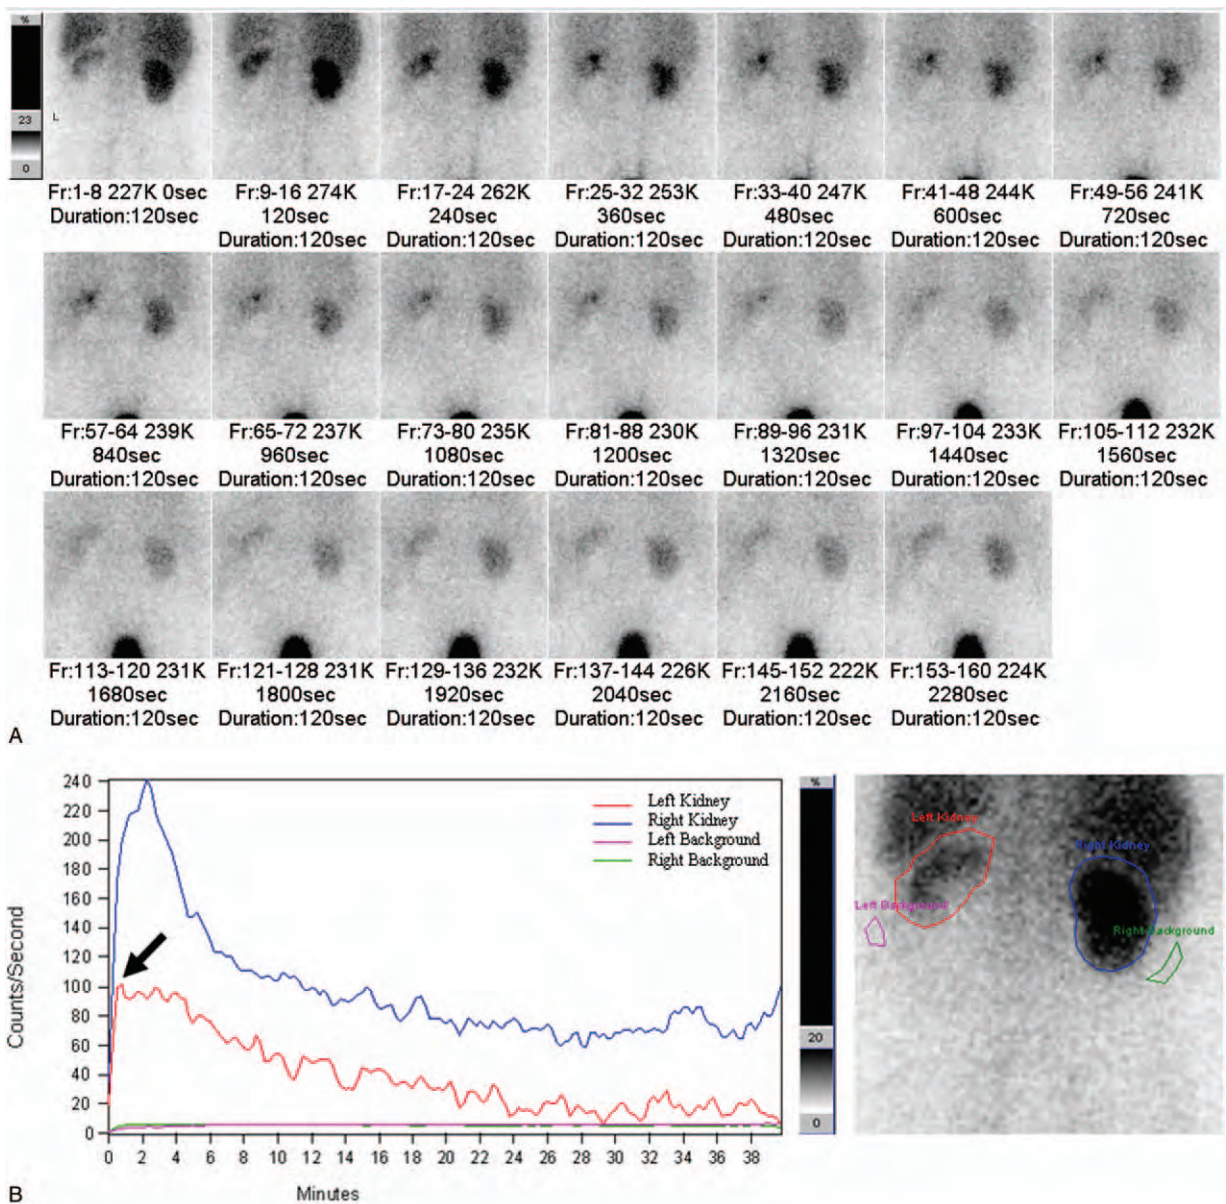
Renoscintigraphy with sequential scintiphotos (A) and time-activity curve (B) after operation disclosed improvement of renal flow of left kidney (arrow).
